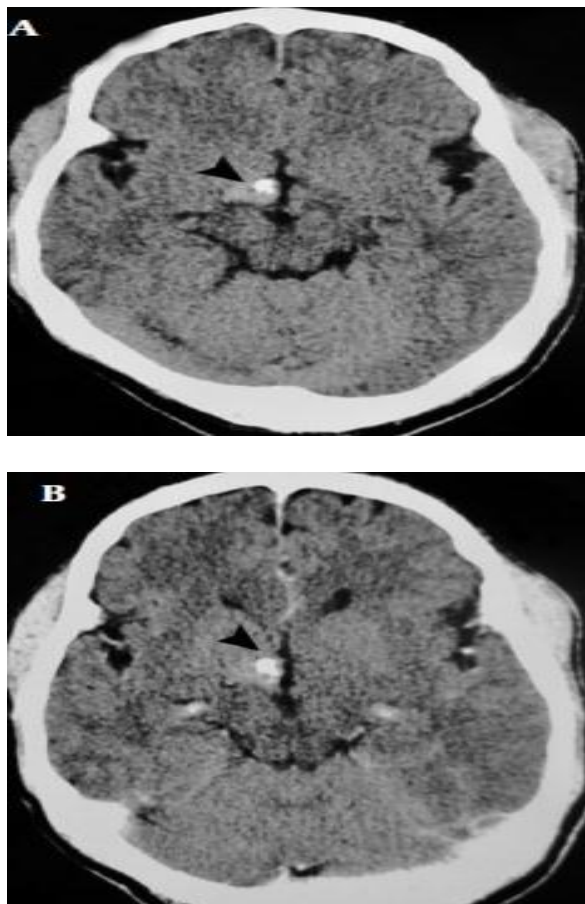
Axial Non-Contrast Computed Tomography, B – Axial Contrast Enhanced Computed Tomography – Shows A Mildly Enhancing Hyperdense Nodular Lesion On The Right Side Of The Hypothalamus With Punctate Calcification (Arrowhead) Without Surrounding Edema Or Mass Effect.
